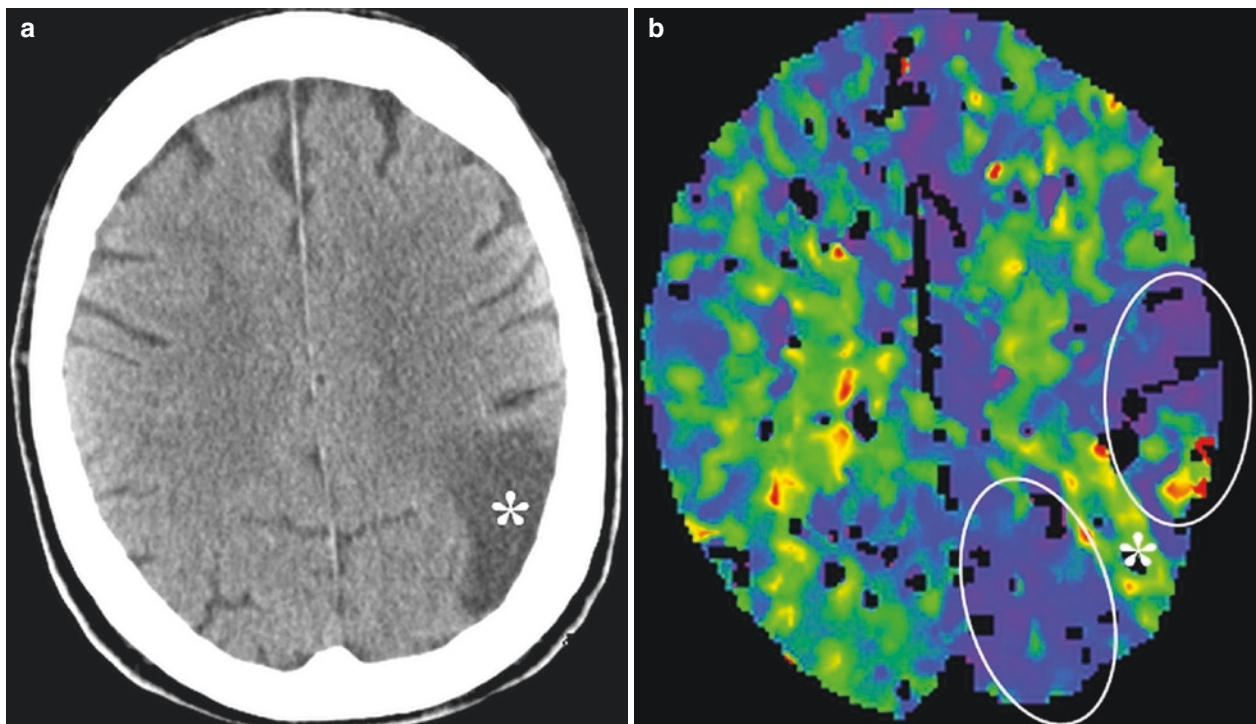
Seizure-related hyperperfusion (ictal phase). Patient presents with right-sided weakness after a witnessed seizure. (a), NCCT shows encephalomalacia in the left parietal lobe (*) and no other acute findings. (b and c), CT perfusion images with time to drain (TTD) (b) and cerebral
